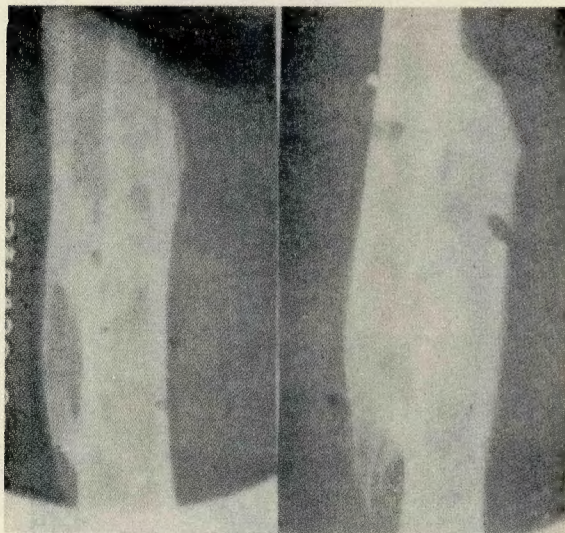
(Record No. 194, I.S.N. 731028) Roentgenogram showing marked overriding of fracture of middle third of right femur.
